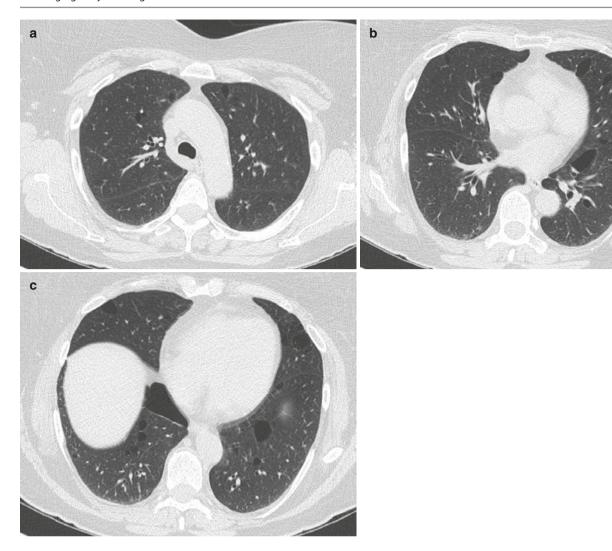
Birt-Hogg-Dubé syndrome in a 43-year-old woman with renal cell carcinoma. (a-c) Axial CT images show variable-shaped cysts with few cysts in paracardiac location
